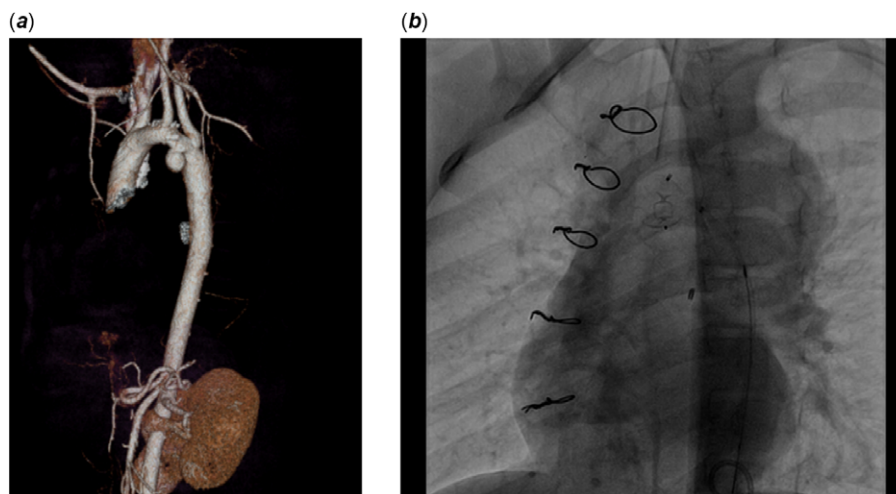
(a) CT shows a 34 mm pseudoaneurysm arising from the transverse aorta. (b) control angiograms after a 6/6 mm amplatzer atrial septal defect occluder deployed.
